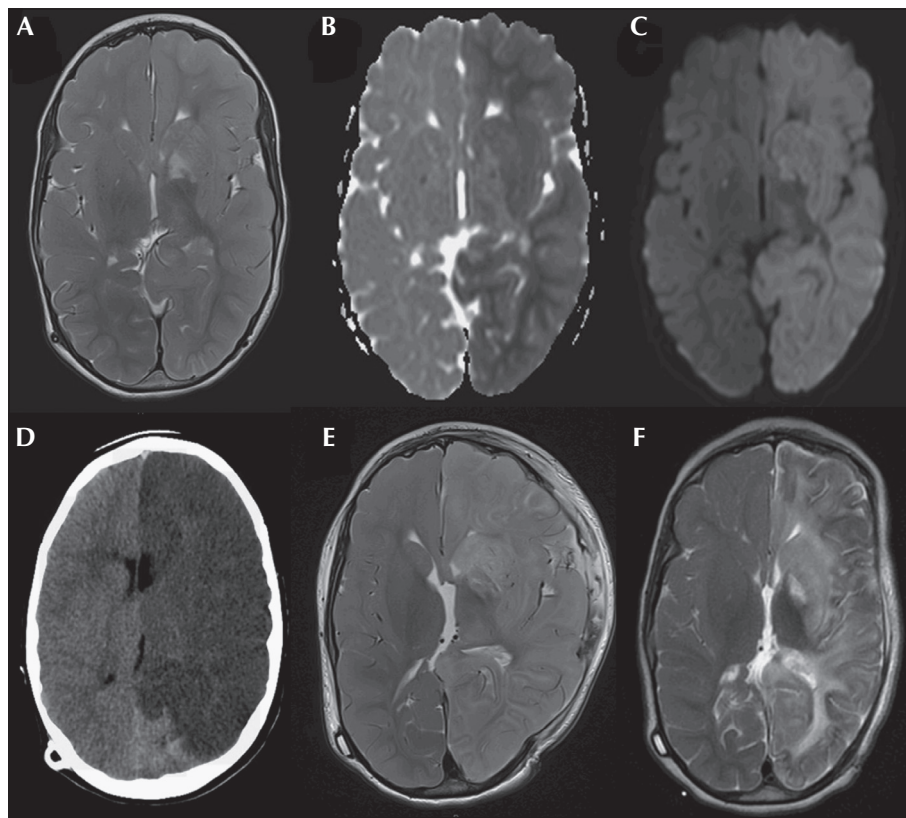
Neuroimaging following status epilepticus presentation. Brain MRI on Day 2 of acute presentation showed diffuse cytotoxic oedema of the left hemisphere, demonstrated by hyperintensity on T2-weighted sequences (A), hypointensity on apparent diffusion coefficient mapping (B), and hyperintensity on diffusion weighted imaging sequences (C).
